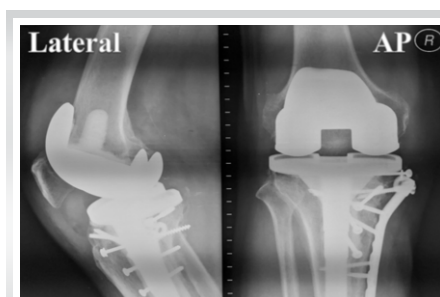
One year follow-up X-ray of the fracture treated with primary arthroplasty and plating. (Credits – Asikin et al.).
